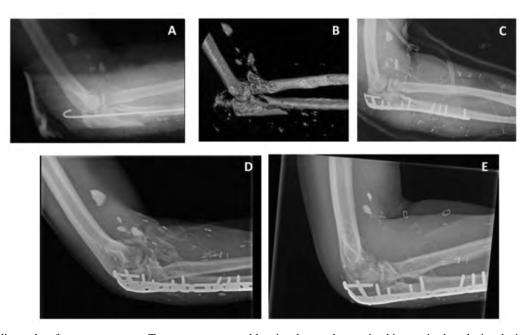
Serial radiographs of treatment course. Twenty-seven-year-old active duty male sustained improvised explosive device blast injury to the left upper extremity while serving in Afghanistan as an explosive ordinance disposal team leader, resulting in a Gustilo-Anderson type IIIB open proximal ulna and radial head fracture-dislocation. He was treated for TBI. He underwent irrigation and debridement and provisional stabilization prior to arrival at our facility. Radiographs (A) and CT 3D reconstruction (B) are shown. He underwent serial irrigation and debridement. After anterolateral thigh free tissue transfer, we performed open reduction internal fixation (C) 11 days after injury. After three postoperative months, he returned with elbow HO and contracture (D) that was refractory to therapy and splinting. His arc of motion was 25 to 65 degrees of flexion. HO resection was performed six months after definitive fixation, followed by intensive occupational therapy. Post-resection (two weeks postoperative) radiographs are shown (E). At two years follow-up, his arc of motion was 30 to 115 degrees of flexion.
